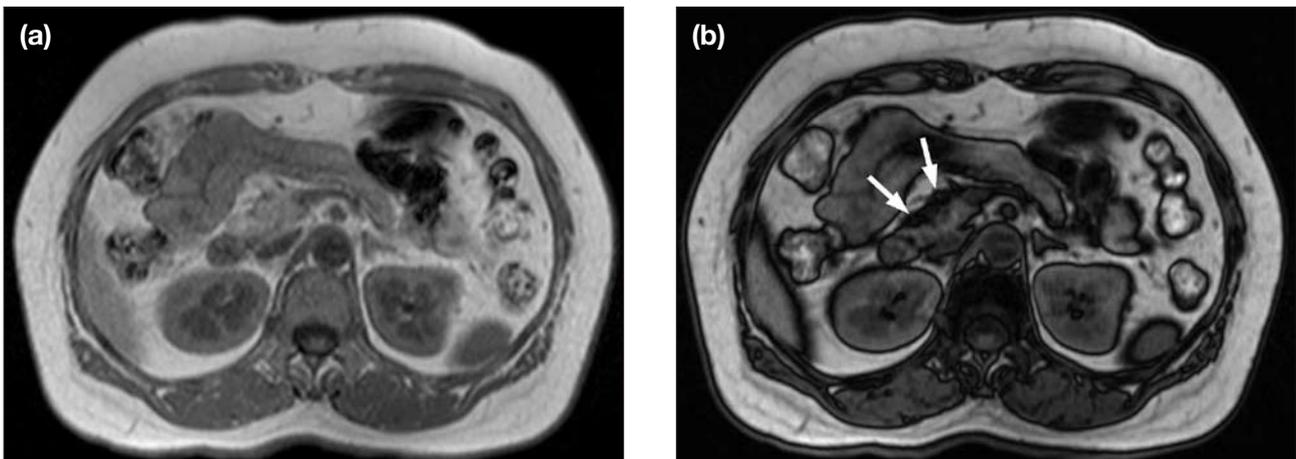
Chemical shift magnetic resonance images of the pancreas. (a) Transverse gradient-echo T1-weighted in-phase image showing no abnormality in the head of the pancreas; and (b) transverse gradient-echo T1-weighted opposed-phase image showing a hypointense lesion (arrows) in the head of the pancreas.
